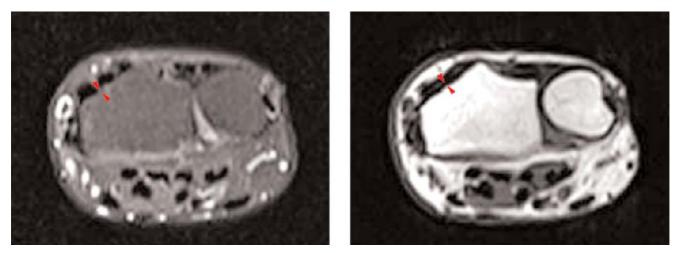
Cortical bone measurements on the distal radius. Cortical bone is demonstrated by red arrows in both T1- and T2-weighted images of the same section.
